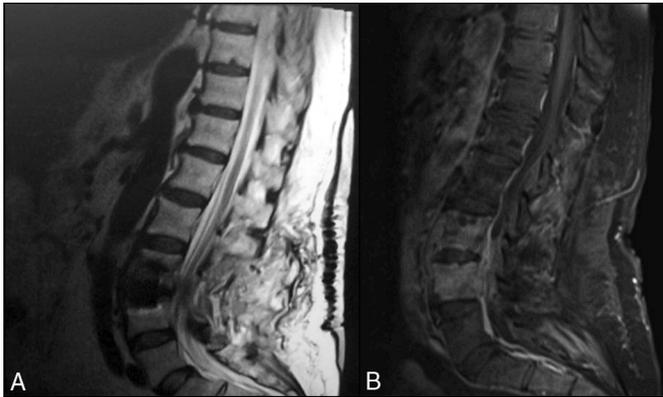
(A and B) Magnetic resonance imaging of L3-L4 vertebrae with extensive marrow infiltration, epidural phlegmon, and discitis.
